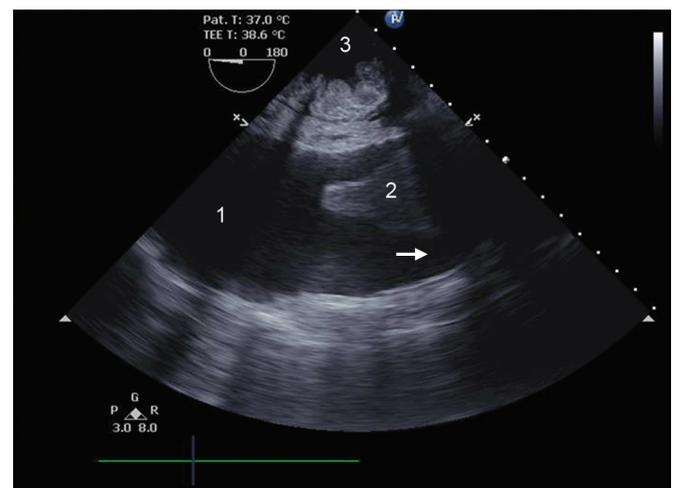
Transesophageal echocardiogram showing the fluid collection (1) with suspected atelectatic lung (2). The direction of the “Tiger’s claw” sign (arrow) points toward right indicating a right-sided pleural effusion. Reexamination with additional intraoperative findings identified the fluid as intraperitoneal and (2) as spleen. (3) Gastric cavity
